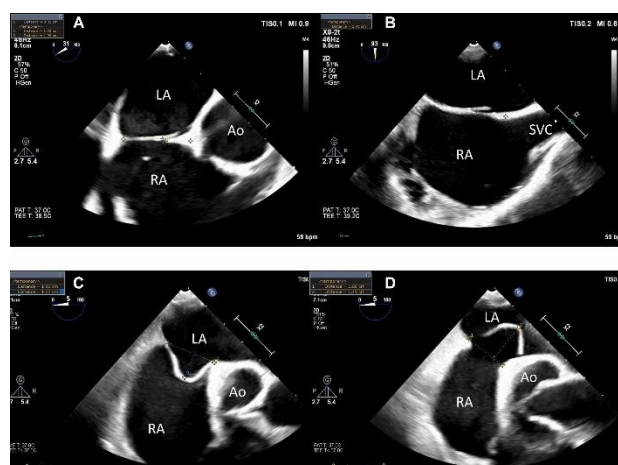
Transesophageal Echocardiography Patent Foramen Ovale
